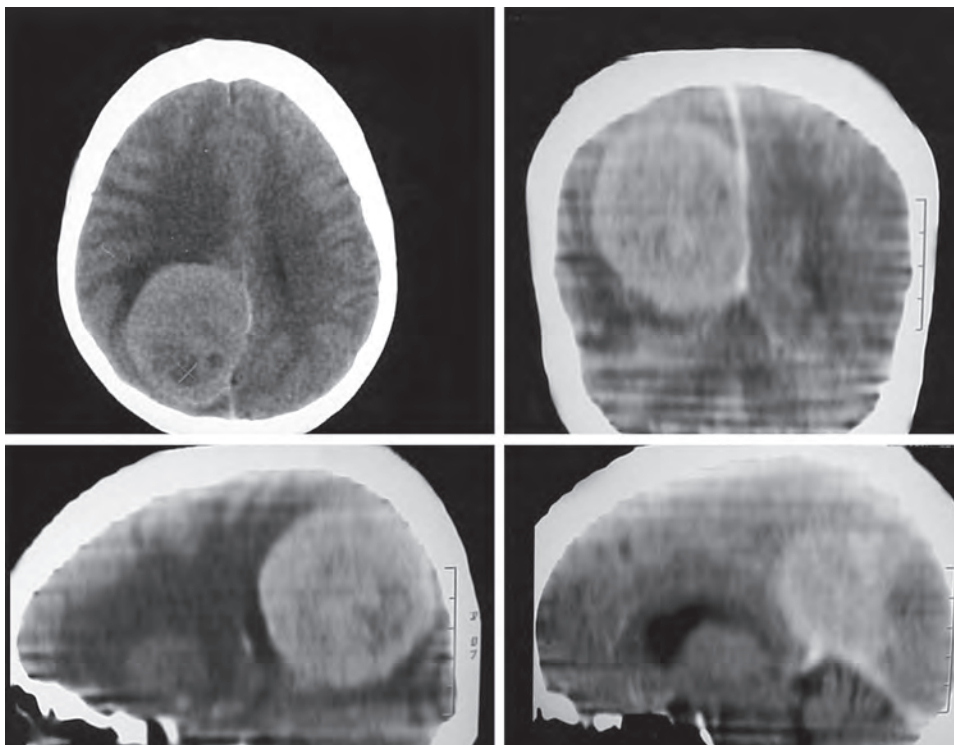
CT scan of the brain showing a large posterior-third falx meningioma
